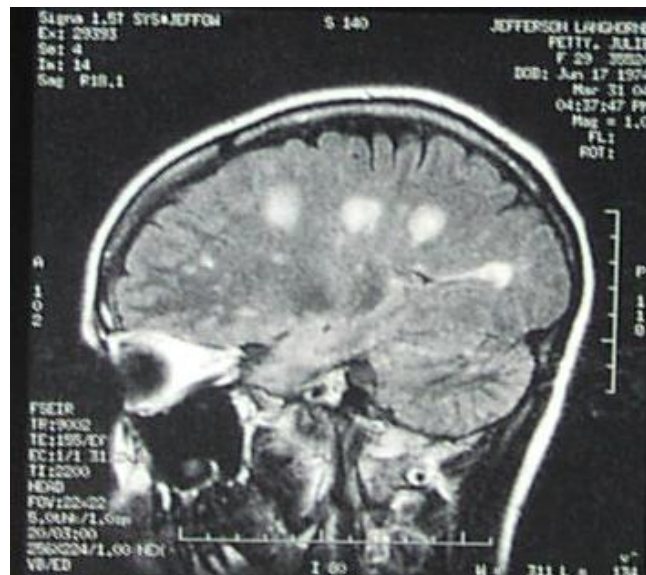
Sagittal MRI brain scan demonstrating sclerotic plaques in the white matter in a patient with MS.
